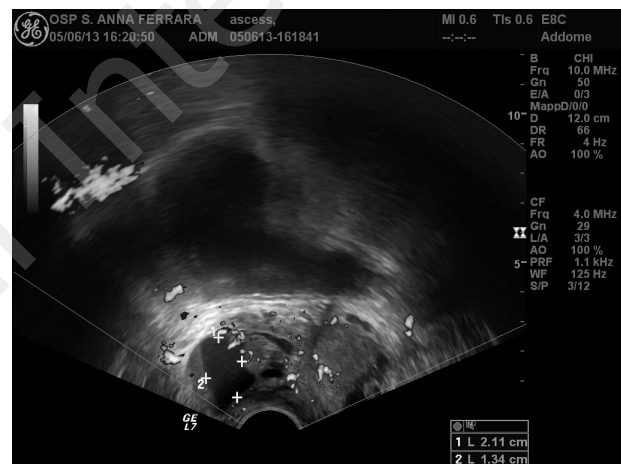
Power Doppler sonogram shows perilesional hypervascularity.
